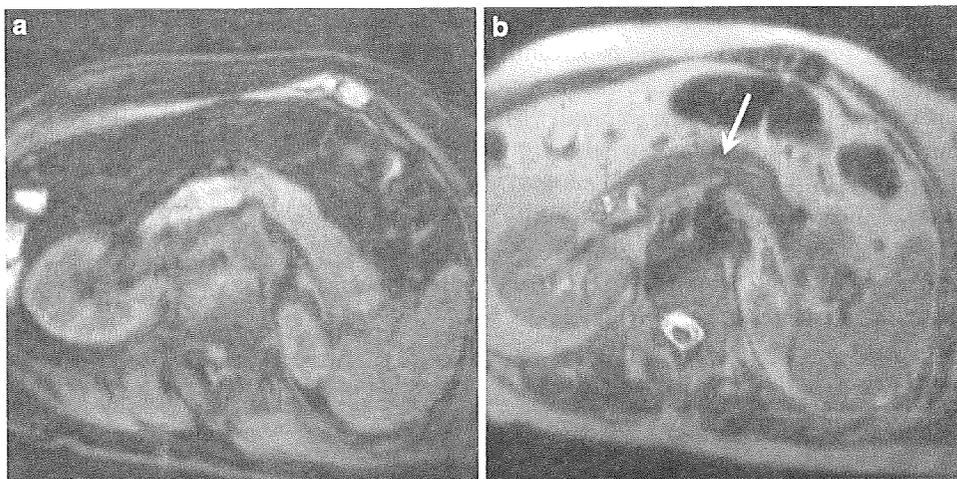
a Contrast-enhanced CT of pancreatic cancer shows a localized mass lesion in the pancreatic head in the early phase. b In late phase, delayed heterogeneous enhancement was seen in the mass lesion
